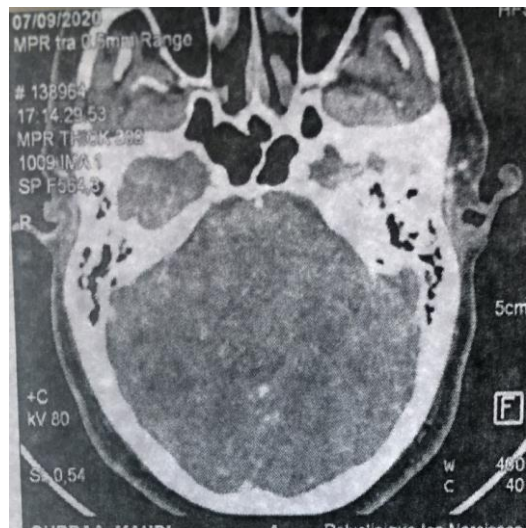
Axial section of a CT scan showing the process Tumor without endocranial extension.
